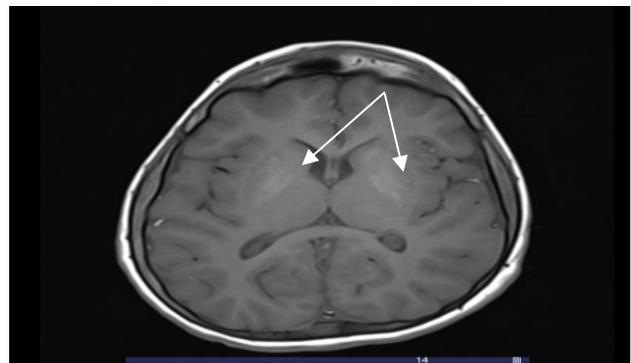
MRI (T1) of basal ganglia calcification.
